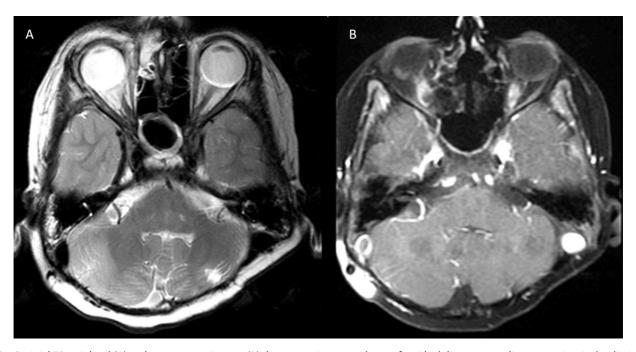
Axial T2-weighted (A) and postcontrast images (B) demonstrating no evidence of residual disease postadjuvant craniospinal radiation therapy and chemotherapy.
